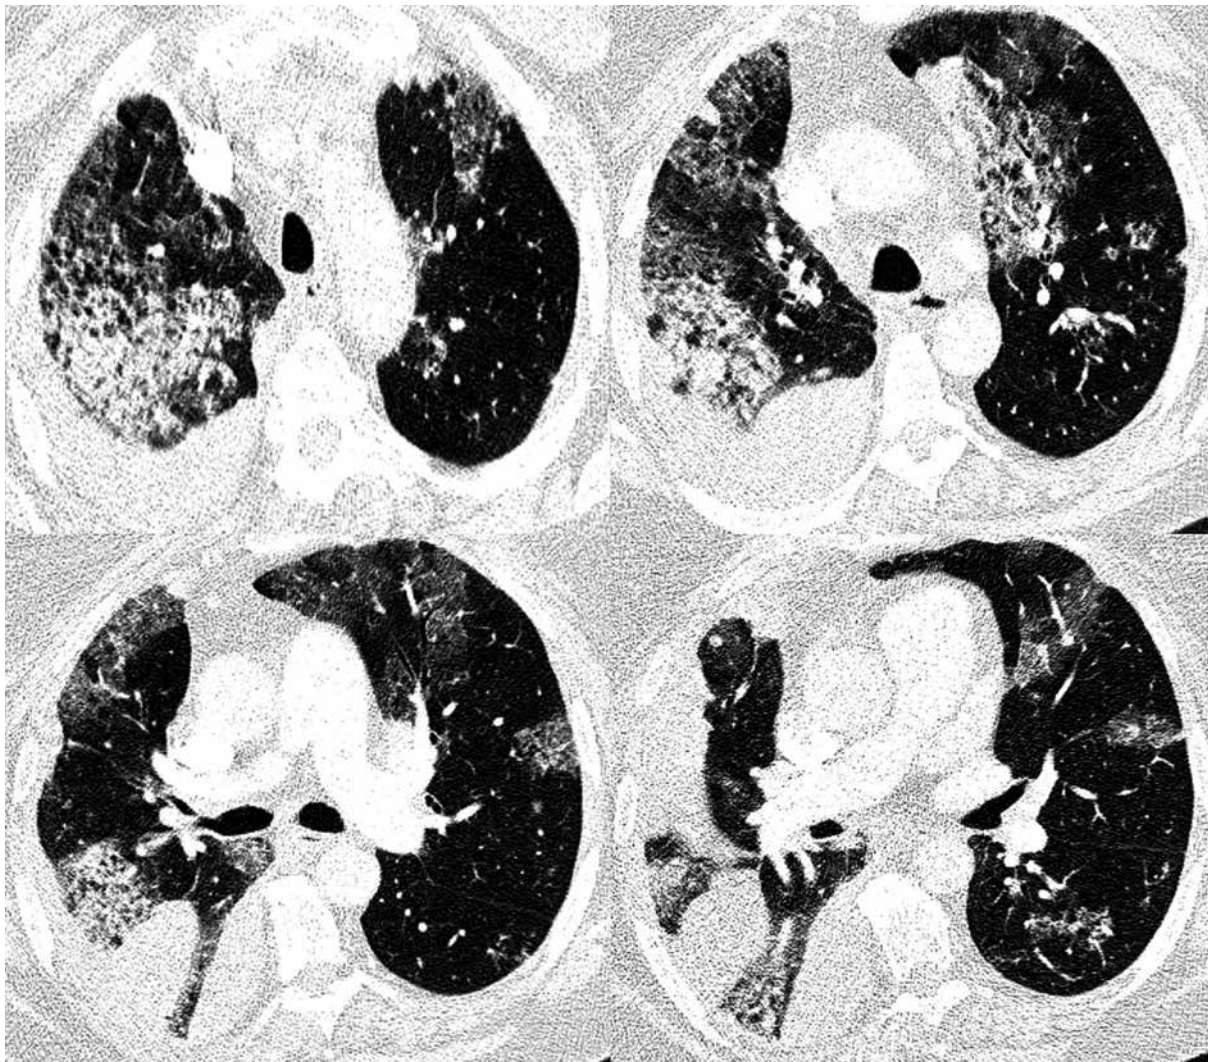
High-resolution computed tomography (HRCT) scans: multiple ground-glass opacities, predominantly subpleural; some small nodules bilaterally
